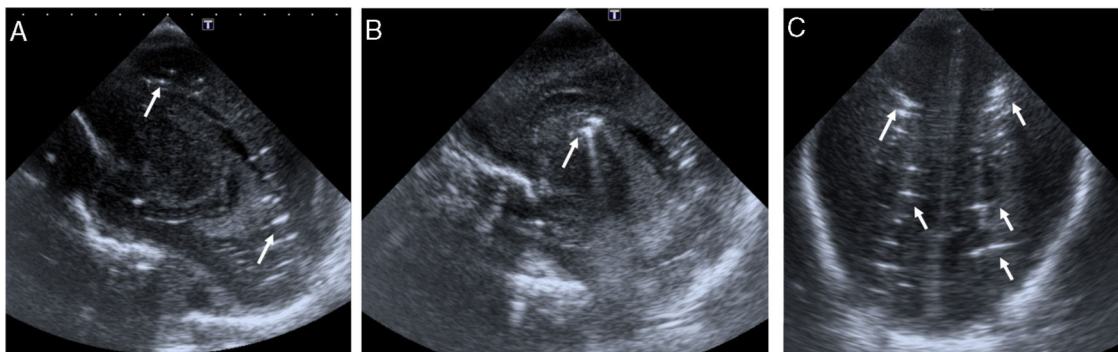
Ultrasound sagittal (A and B) and coronal (C) views showing multiple hyperechoic, birefringent spots and lines in the deep periventricular white matter on both sides of the brain (arrows in A and C) and right caudothalamic groove (arrow in B) that could be attributed to cerebral air embolism.
